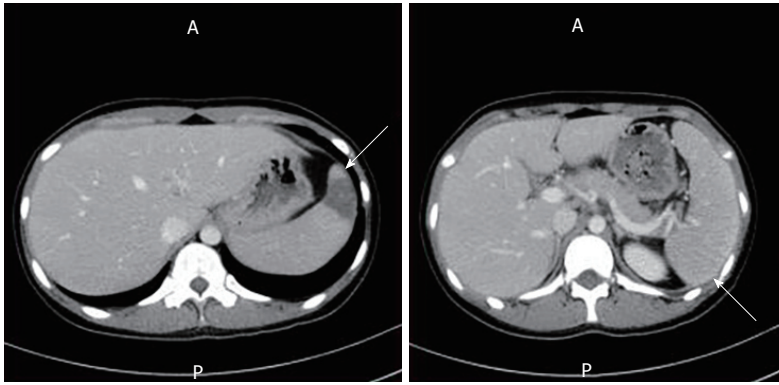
Thoracoabdominal contrast computed tomography scanning. Computed tomography scan showing an area of low density in the spleen, suggesting splenic infarction (left arrow) and splenomegaly (right arrow).
